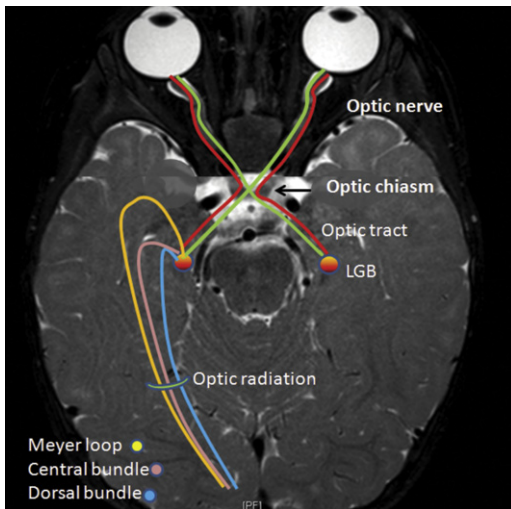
MR image of visual pathway showing optic nerves, chiasm (arrow), optic tracts, lateral geniculate body (LGB), and optic radiations. Anterior, central, and posterior bundles of optic radiation as they course to the occipital cortex are also shown.
